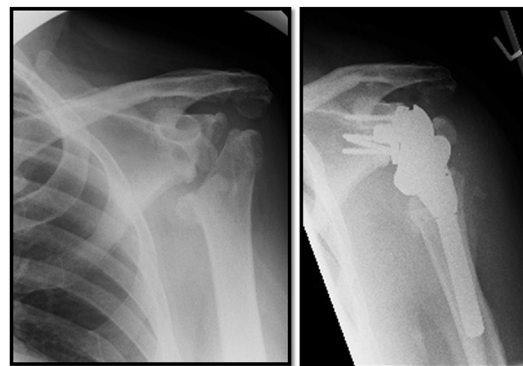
Pre-operative and Post-operative radiographs of the patient operated with reverse total shoulder arthroplasty.
